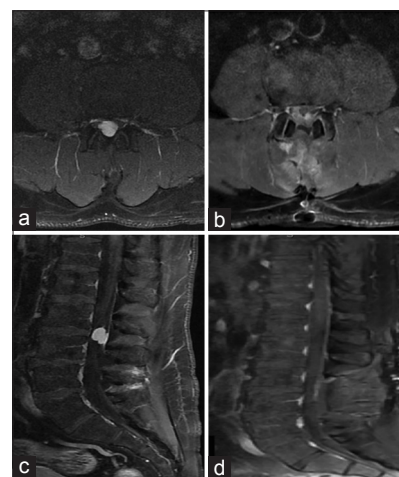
MRI T1+Gadolinium (a) Preoperative axial image (b) Postoperative showing gross total resection (c) Preoperative sagittal image (d) Postoperative image showing improved cauda equina mass effect
